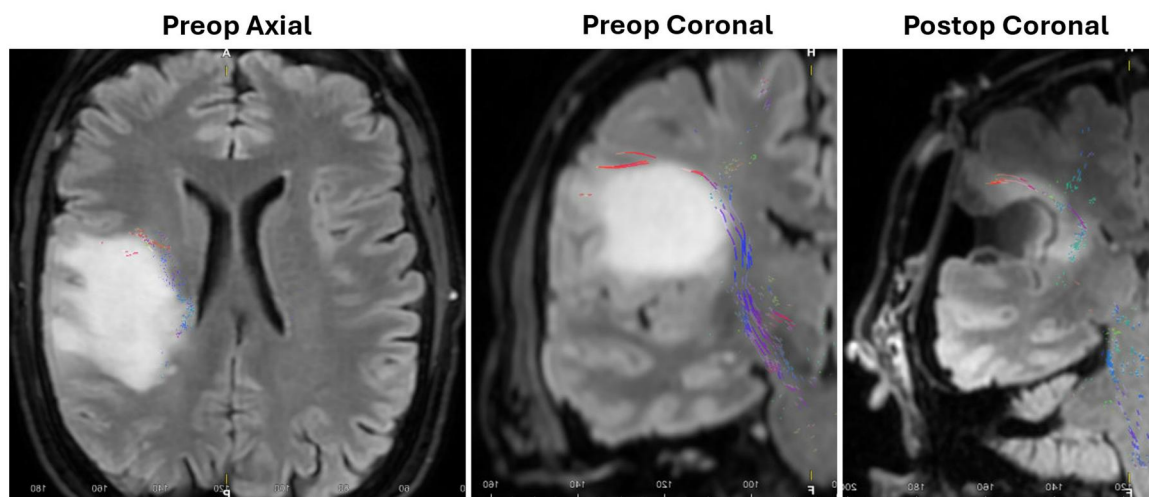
FLAIR MRIs from a 70-year-old female with a right frontoparietal diffuse pediatric-type high-grade glioma, H3-wildtype and IDH-wildtype, MGMT-met, WHO grade 4, who underwent a maximal safe resection of her lesion. The infiltration of the tumor into the corticospinal tracts (colorful lines) prevented a gross total resection in this case.
